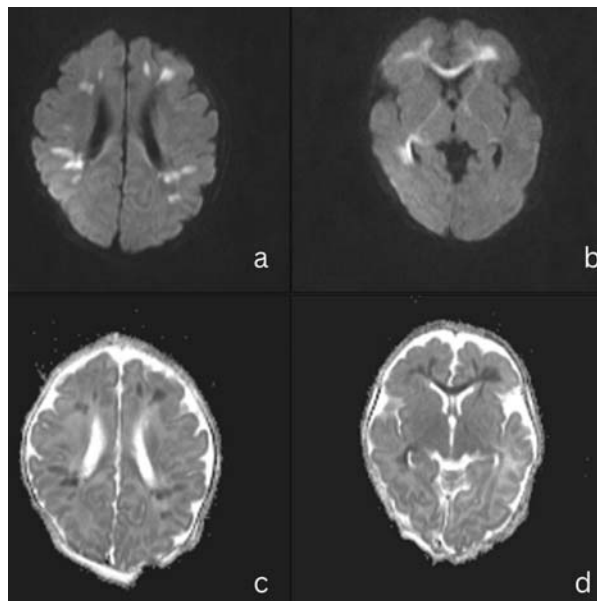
Magnetic resonance imaging of brain, axial sections showing hyperintensity over the subcortical white matter and the genu of corpus callosum (a and b) in diffusion weighted imaging (DWI) and hypointensity over the corresponding areas in ADC map (c and d) suggestive of diffusion restriction indicating cytotoxic brain edema.
